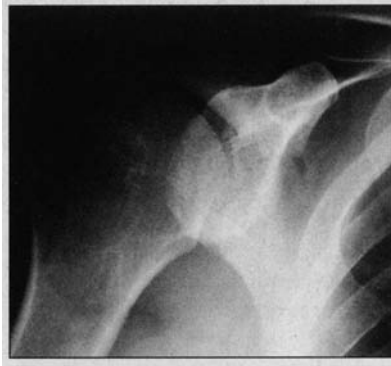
Lateral radiograph of normal shoulder.
